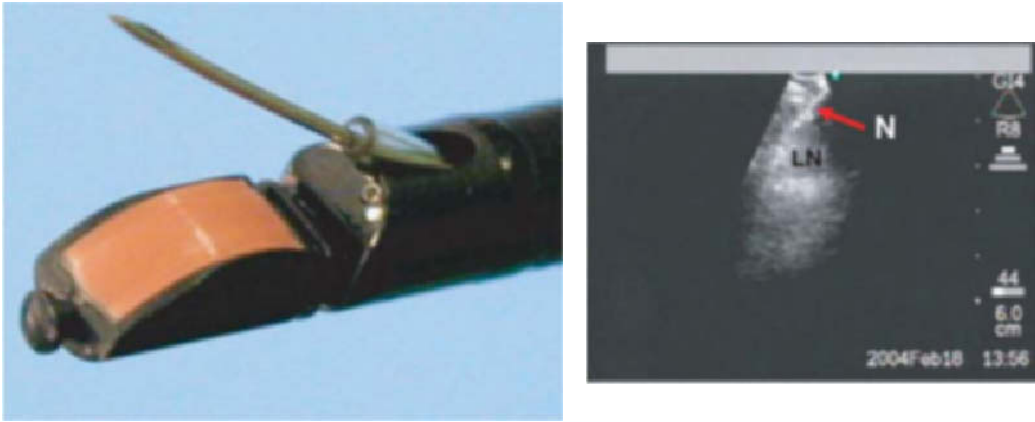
The ultrasonic bronchoscope with linear electronic transducers at its tip (Olympus Co., Tokyo, Japan) allows direct visualization of the needle (N) for guidance of transbronchial needle aspiration of mediastinal lymph nodes (LN).
